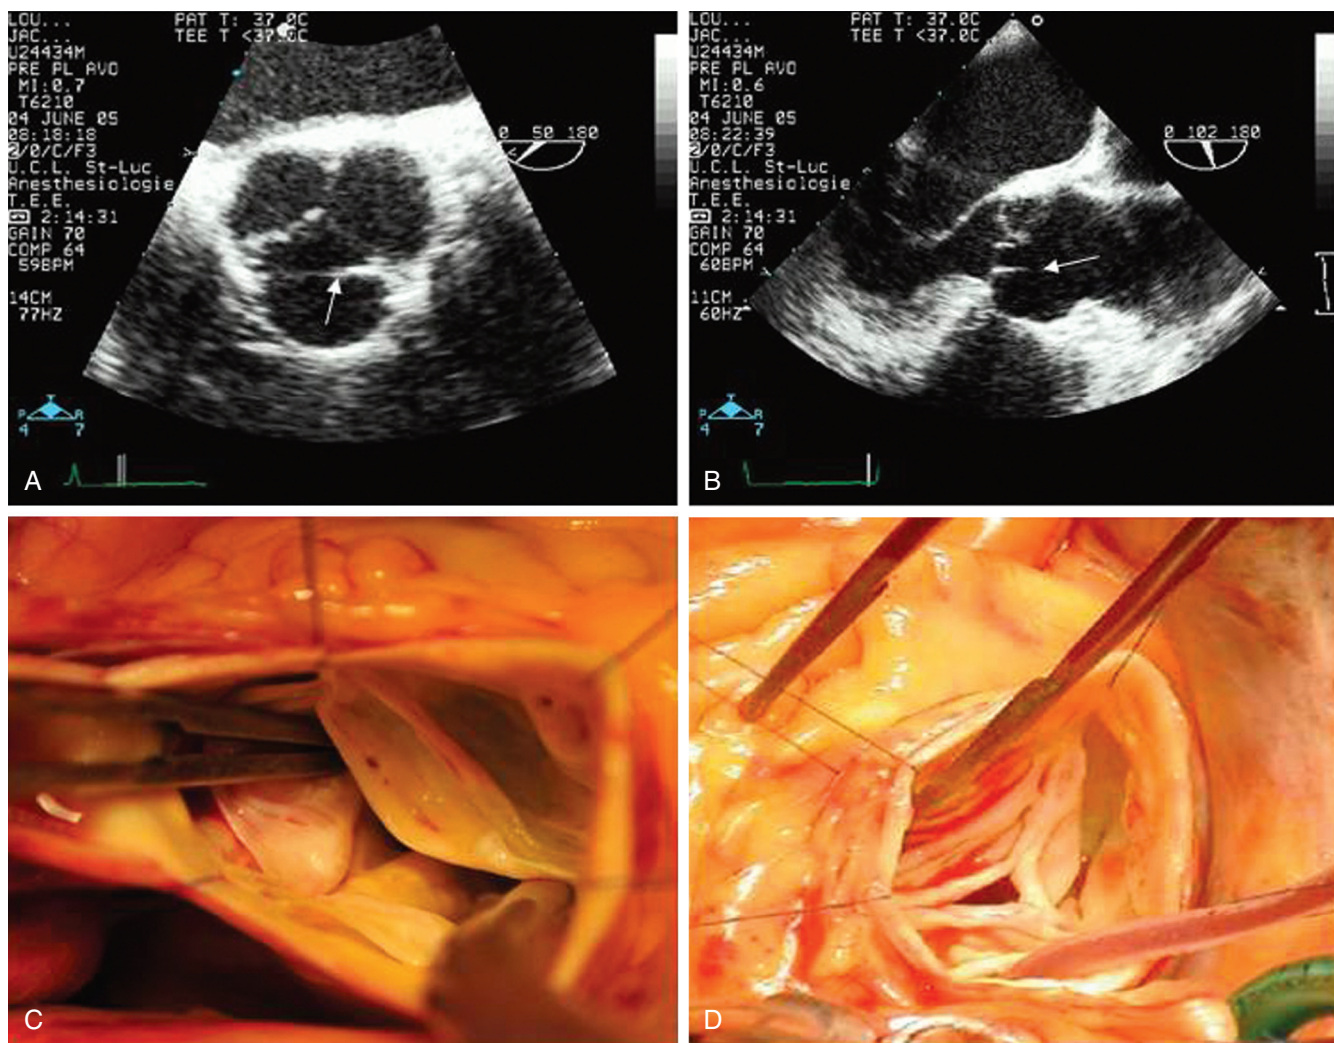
■ A and B, A transverse fibrous band is typically visible on echocardiography (arrow) and surgical inspection (C, D) in the setting cusp prolapse in trileaflet aortic valves and may help in the detection and localization of cusp prolapse.
